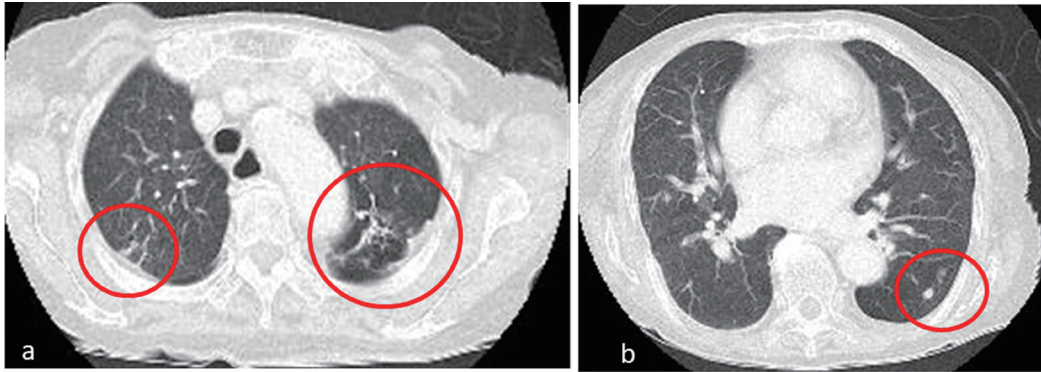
Chest computed tomography images on admission.
